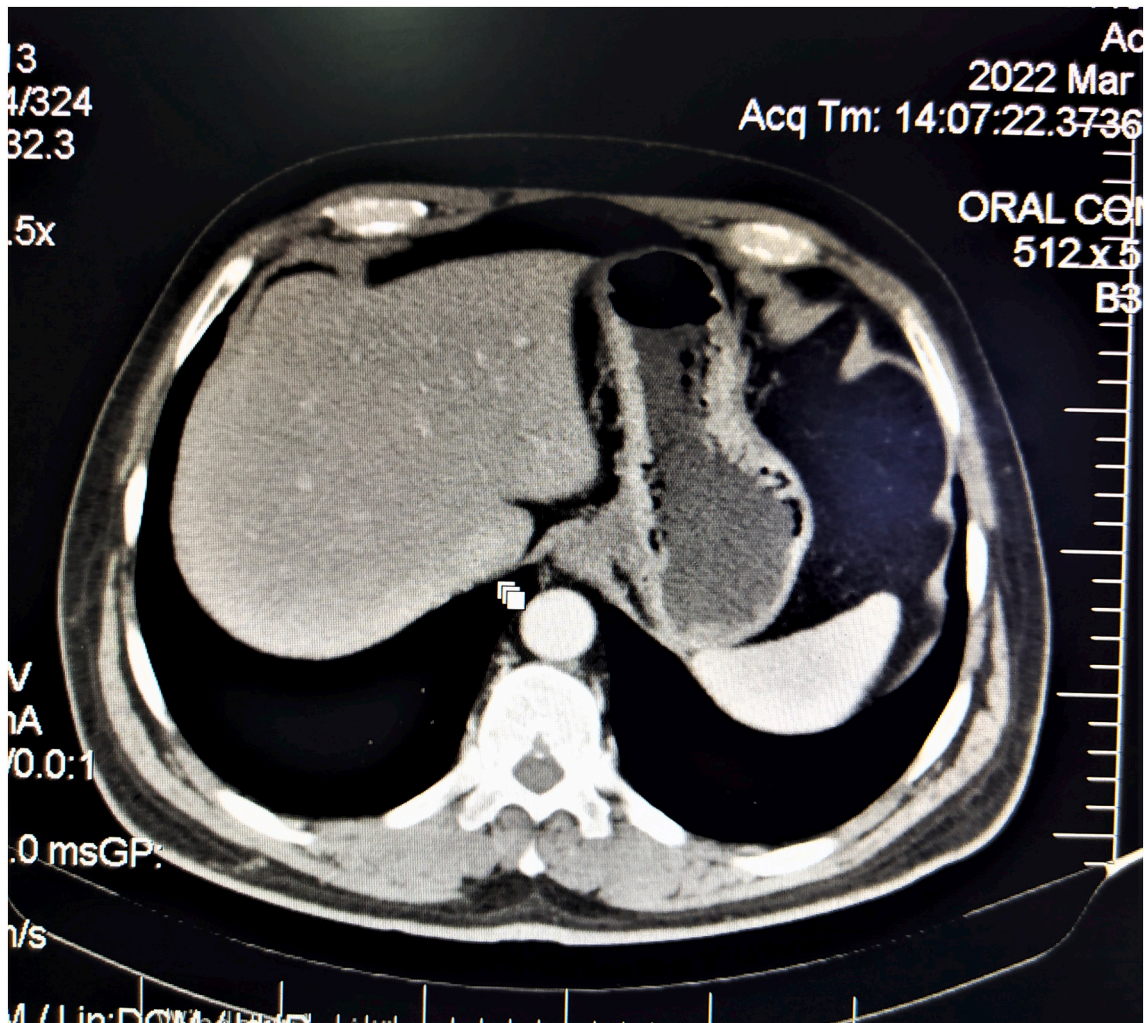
Preoperative CT scan cross sectional view revealed no invasion of vital organs such as bladder, liver, spleen, pancreas, and adrenal structures.
